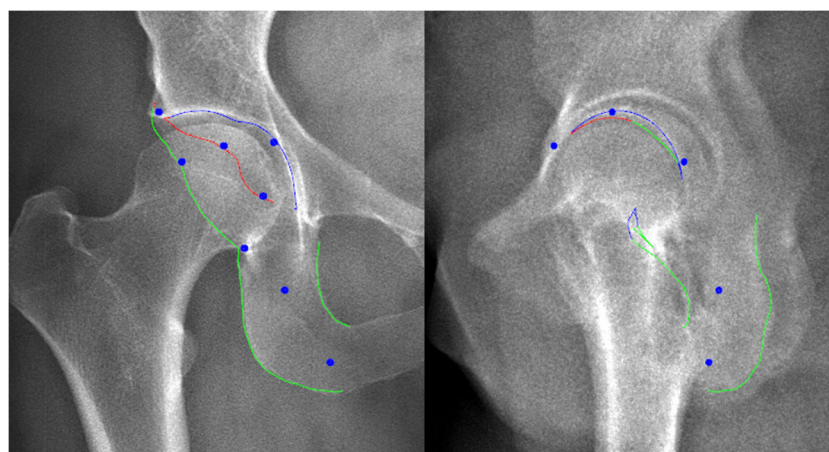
Anteroposterior and lateral images of the biplanar radiographs (BPR) of the right hip joint in a 45-year-old male patient. The blue points represent critical landmarks that can be adjusted manually to influence the contours of the acetabulum
